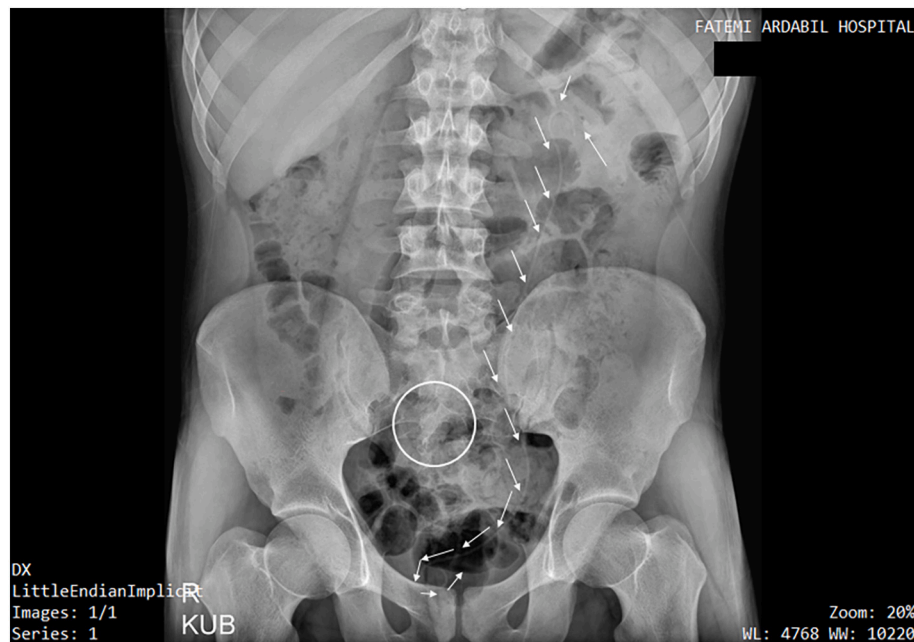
A kidney, ureter, and bladder X-ray after the second surgery revealing the proper double J tube placement (order of arrows), successful removal of the bullet and pieces of evidence of laminectomy (circuit).
